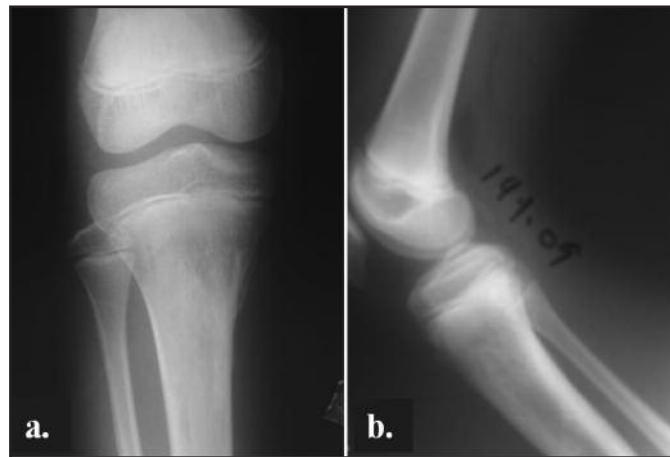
Case 1: Anteroposterior (a) and lateral (b) plain radiographs at 18 months after treatment showing a complete recovery.
